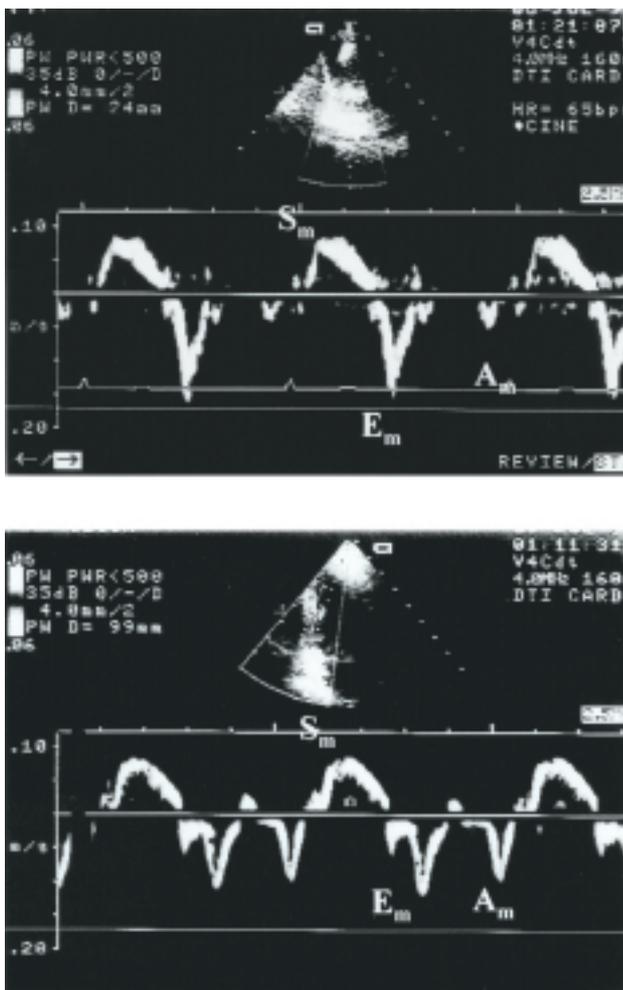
Pulsed wave Doppler tissue imaging pattern with the sample volume placed at the level of the left ventricular inferior wall in an endurance- (upper panel) and in a strength-trained athlete (lower panel). A_m = myocardial atrial diastolic wave; E_m = myocardial early diastolic wave; S_m = myocardial systolic wave.
